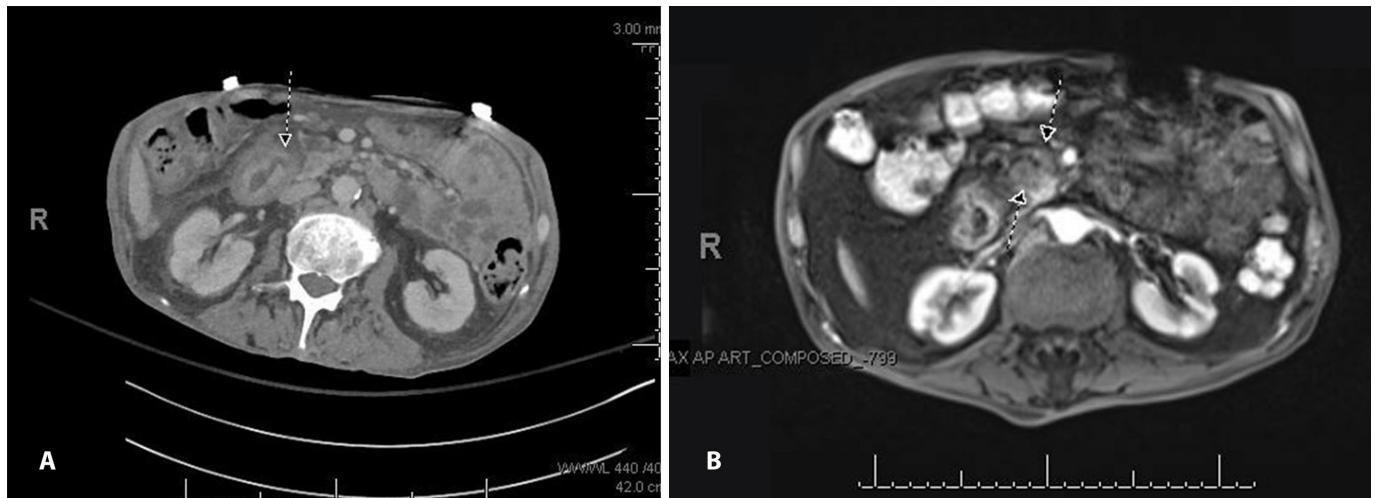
(A) Dilation of main pancreatic duct up to 5 mm shown on abdominal CT. (B) Abdominal MRI demonstrating an ill-defined soft tissue in the pancreatic neck/head measuring 2.8×2.2 cm, obstructing the pancreatic duct.
